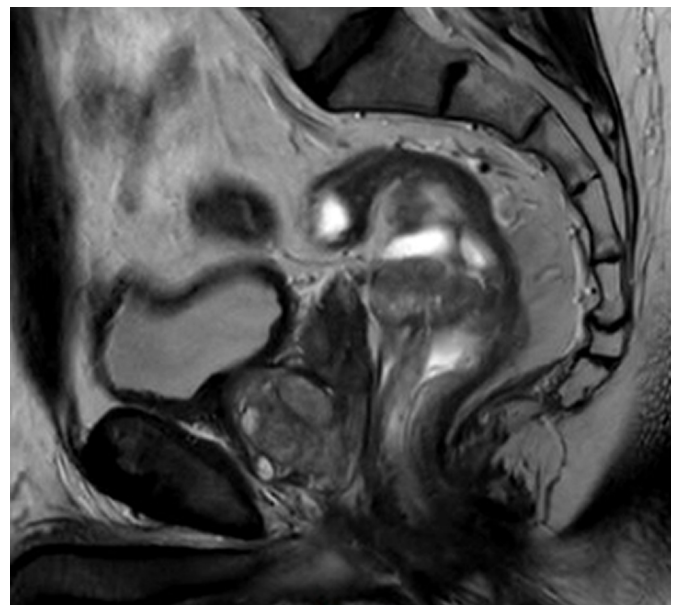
Sagittal view of rectal tumor on magnetic resonance imaging.
